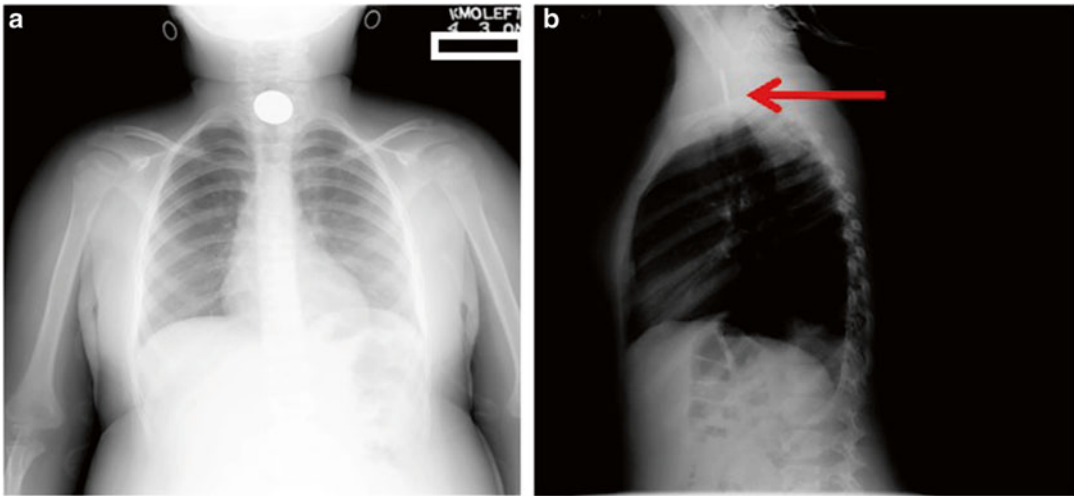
(a) Posterior-anterior chest radiograph in a child shows a rounded metallic object (coin). (b) Lateral view confirms the object to be lodged in the esophagus (*arrow*), not the trachea
